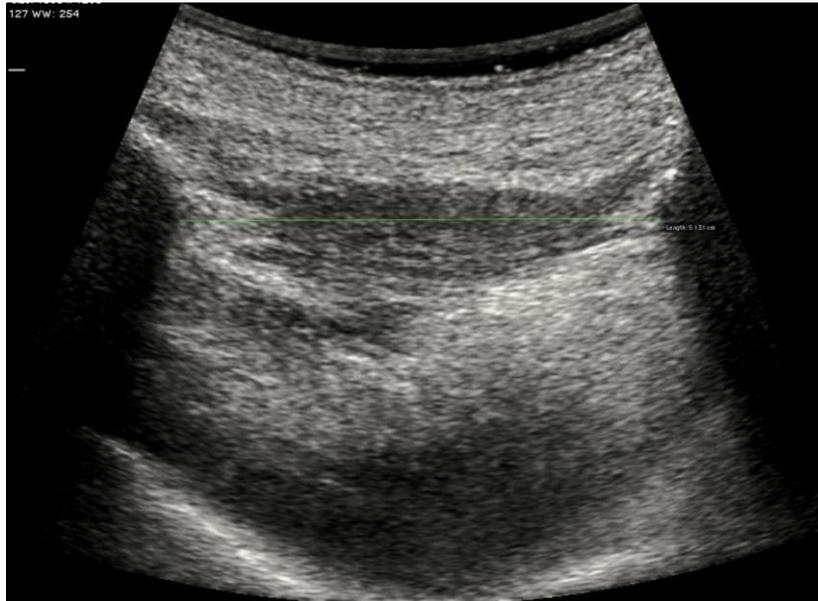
Ultrasonographic image of distance measurement between the reference point (mandible – left) and the hyoid bone (right) at rest
